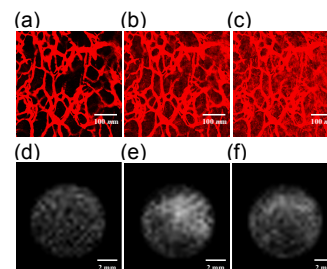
Dynamic time series of tumor in a dorsal window chamber, acquired by CLSM (a: 2min, b: 9min, c: 25min post-contrast) and DCE-MRI (d: pre-contrast, e: 5min and f: 37min post-contrast).
